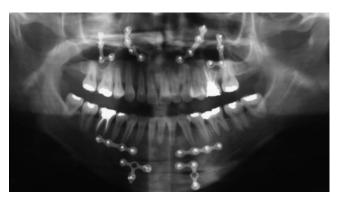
Case 1: post-treatment orthopantomogram
